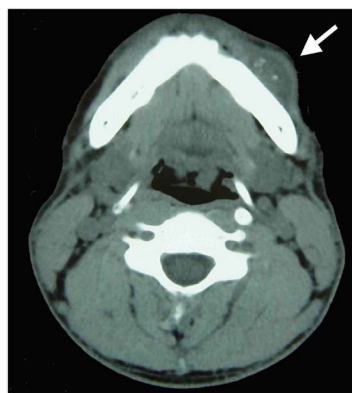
Computed tomography showed a well defined, nonenhancing, $30 \times 27 \times 13$ -mm tumor mass with some calcified tissues in the external left mandible. Mandibular bone was symmetric and showed no apparent abnormality.
